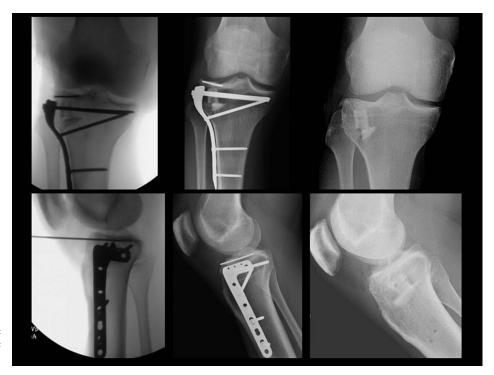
Intraoperative, immediate postoperative and final follow-up radiographs following open reduction internal fixation with structural bone graft, in the form of fibula allograft. Injury films for this fracture can be viewed in Figure 1. Note the anatomic reduction and maintenance of reduction with no evidence of subsidence.
